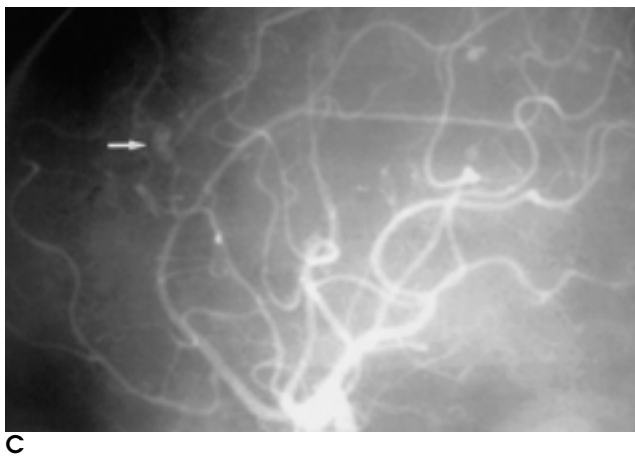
Patient 3. 3-year-old-child who experienced pedestrian injury during walking. Follow-up precontrast CT (A) scan on 140th day shows nodular high density (arrow) around the anterior falx. Postcontrast CT (B) scan shows strong nodular enhancement (arrow) at the lesion. Internal carotid angiogram (C) shows an aneurysm (arrow) at the origin site of the first branch of the callosomarginal artery.
